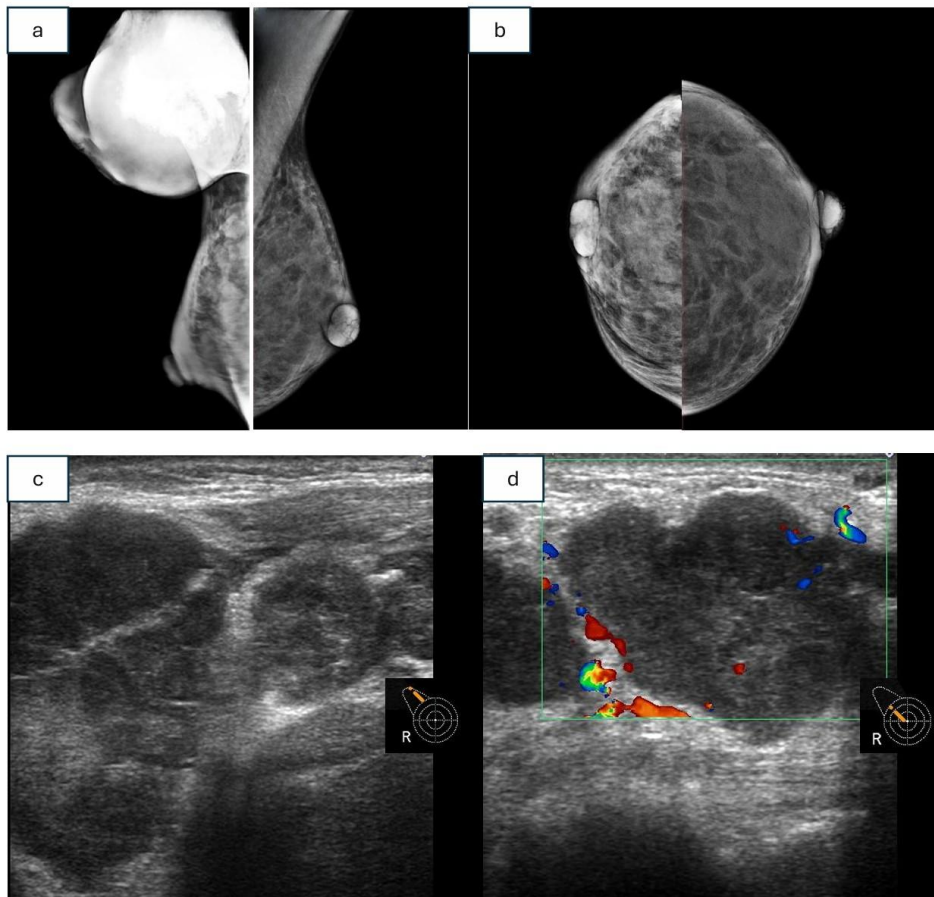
Mammography features (a) MLO view: Large high-density mass at right upper outer quadrant extending to axilla; (b) CC view: Few high density mass with some indistinct margin of right breast. Ultrasound features; (c) & (d) Lobulated hypoechoic masses at right upper outer quadrant extending to axillary region with increased vascularity on color Doppler flow.
